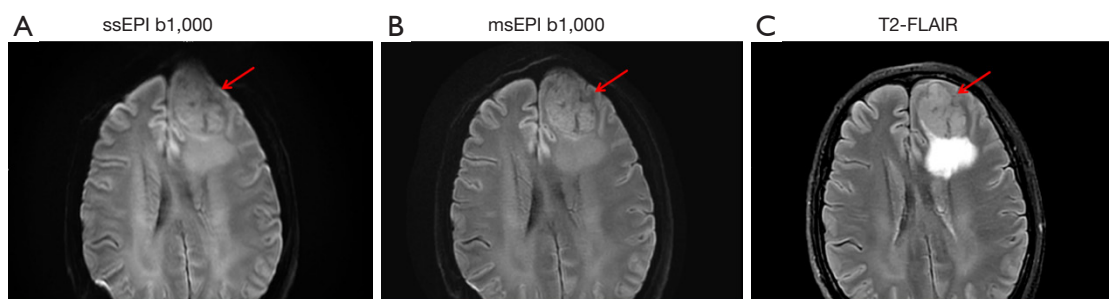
A 55-year-old female patient with meningioma. (A) The meningioma lesion (red arrow) on ssEPI DWI. (B) The meningioma lesion (red arrow) on msEPI DWI. (C) The meningioma lesion (red arrow) on T2-FLAIR. The meningioma lesion appeared less distorted and had a clearer internal structure on msEPI DWI than on ssEPI DWI. ssEPI, single-shot echo-planar imaging; b1,000, $b=1,000 \text{ s/mm}^2$; msEPI, multishot echo-planar imaging; T2-FLAIR, T2-weighted fluid-attenuated inversion recovery; DWI, diffusion-weighted imaging.
